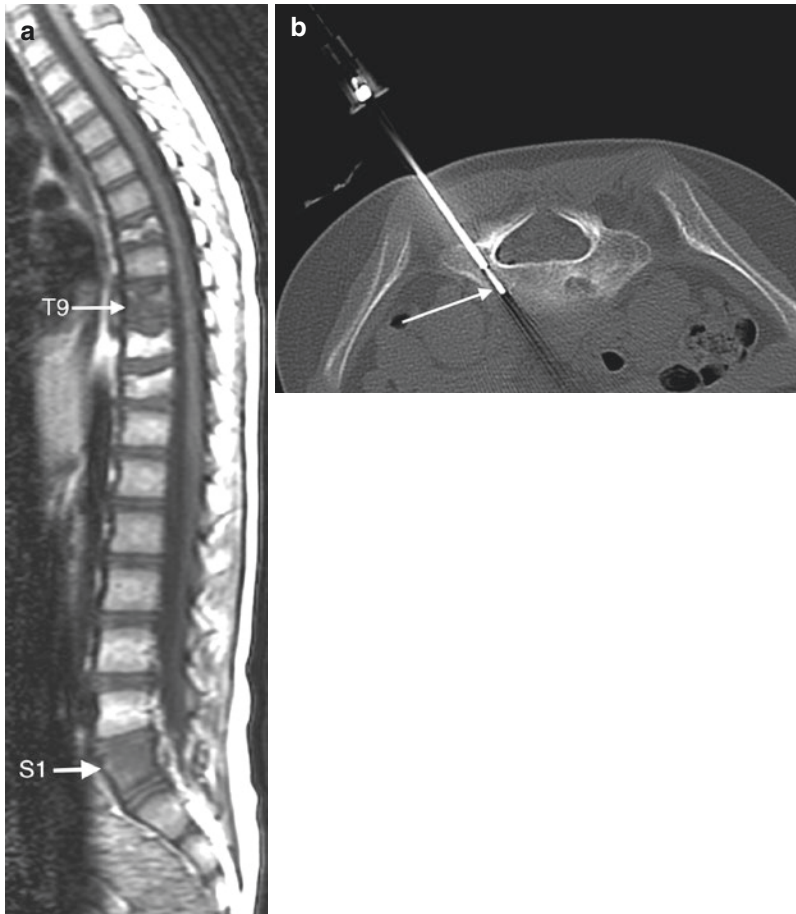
A 7-year-old female with back pain (same patient as in Fig. 5.1). T1-weighted sagittal scout image (a) of the thoracic and lumbar spine shows multiple thoracic vertebral compression deformities and hypointense
